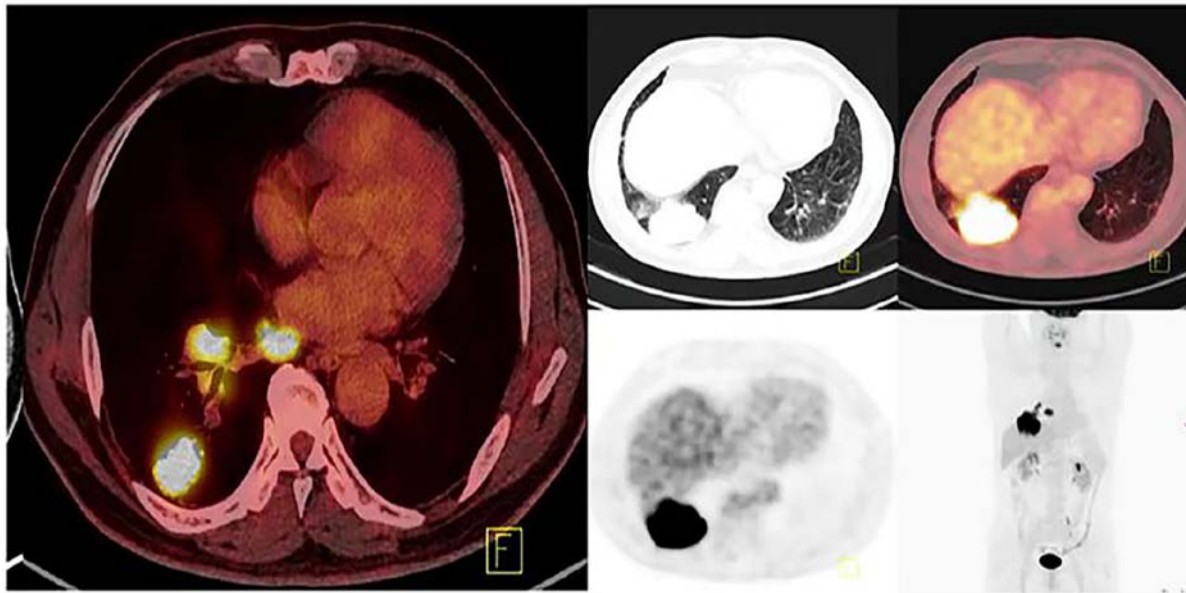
Positron emission tomography-computed tomography image of the patient showing a right lung mass (70x59x56 mm) and enlarged mediastinal lymph nodes before neoadjuvant therapy.
